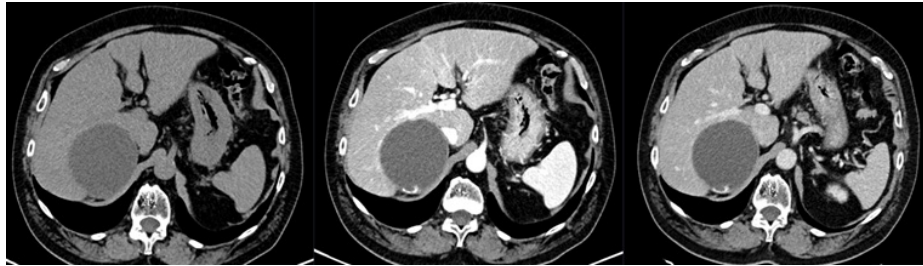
Unenhanced, late arterial phase and portal venous phase CT images (left to right) show a round, encapsulated lesion of the right adrenal gland, with internal cystic content and globular peripheral contrast enhancement.
